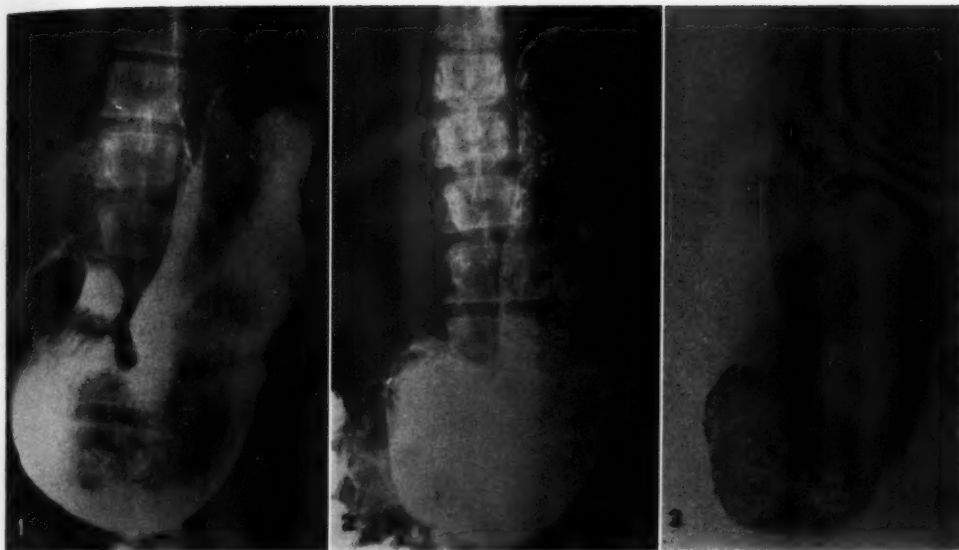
Roentgenogram showing the large trichobezoar as a negative shadow against the opaque medium.
